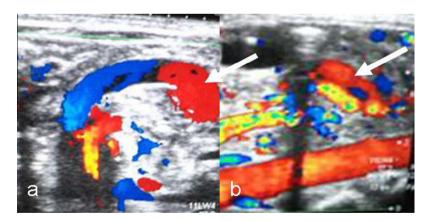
(a and b) Color Doppler sonography images in 21 days neonate with midgut volvulus showing distal SMV dilatation (arrows).
